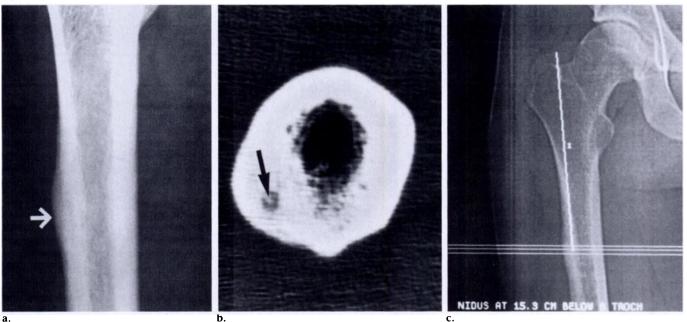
Osteoid osteoma. (a) Anteroposterior radiograph of the femur shows fusiform, benign-appearing cortical thickening of the lateral aspect of the proximal femoral shaft (arrow). A nidus is not evident. (b) Thin-section (3-mm) computed tomographic (CT) image. The intracortical nidus is evident posterolaterally, at approximately the 7-o'clock position (arrow). (c) Measurements for intraoperative planning. The level of the nidus is located on the scout image. A measurement is made from the top of the greater trochanter (a surgically palpable landmark) to the level of the nidus. In this case, the distance measures 15.3 cm.
